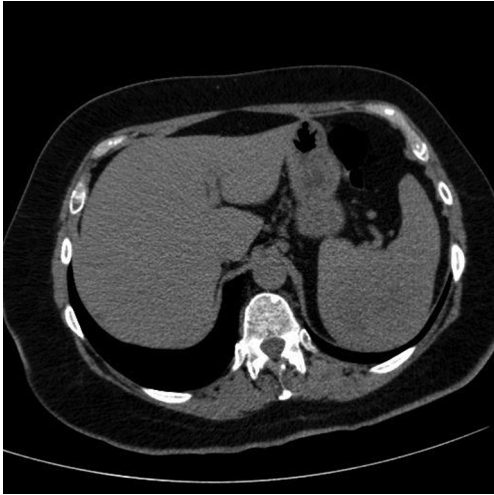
Axial CT reveals an isoattenuated spleen lesion in the pre-contrast images.
